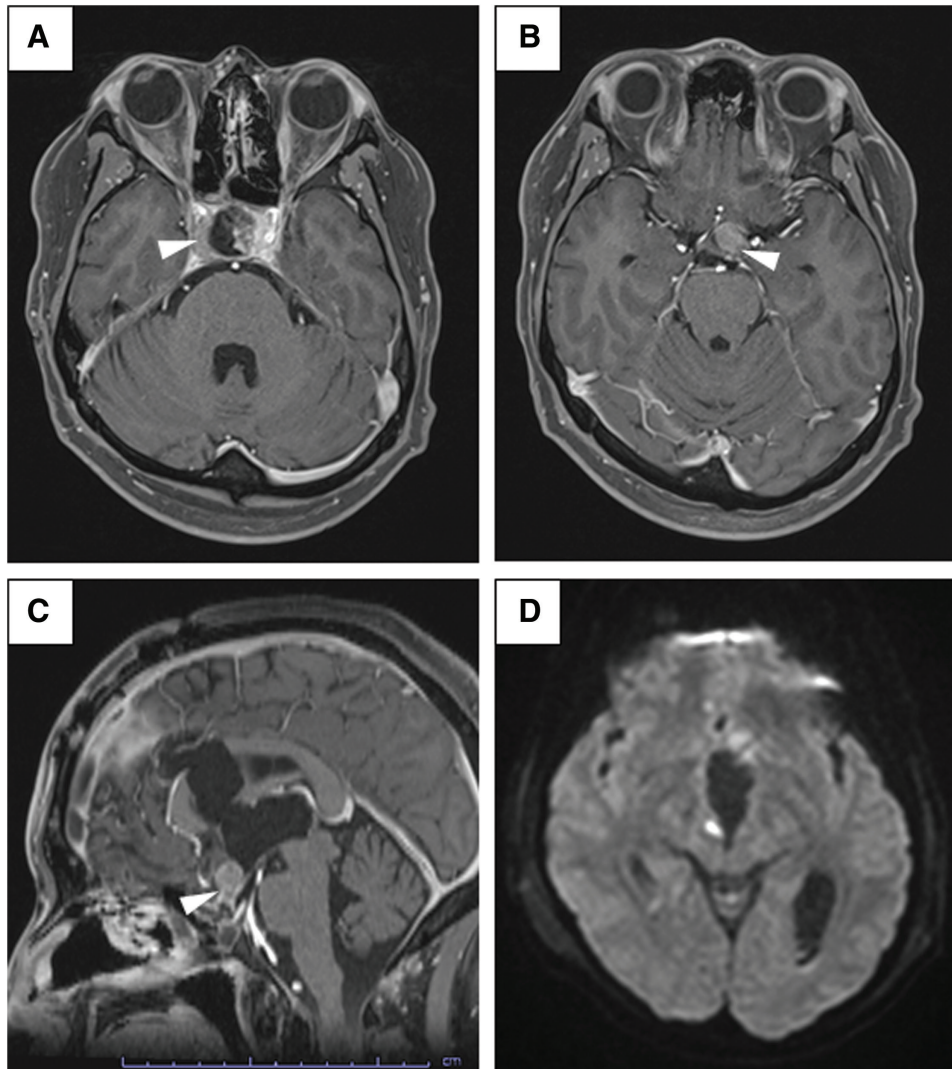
Postoperative residual tumor characteristics in the 41-year-old patient. (A) Postoperative Gd-T1WI showing the small residual tumor (arrowhead) in the right cavernous sinus and (B and C): behind the AComA; most of the tumor was removed sufficiently. (D) Diffusion-weighted image showing a high-intensity signal around the right midbrain cerebral peduncle, but damage in other brain areas is not observed. Gd-T1WI: gadolinium-enhanced T1-weighted MRI, AComA: anterior communicating artery.
